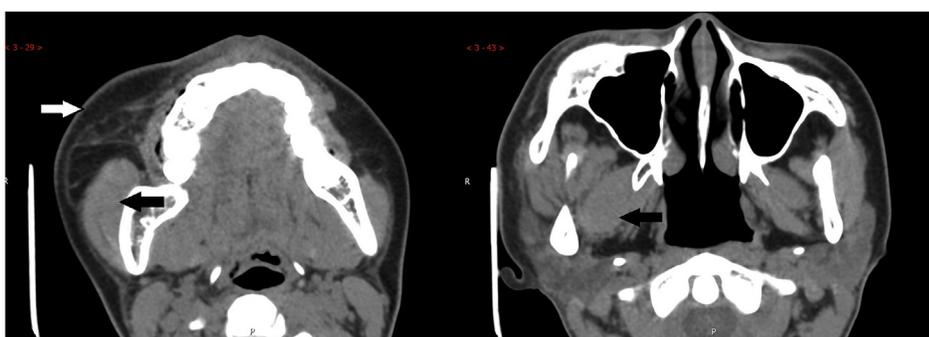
Axial computed tomography shows the fat infiltration in the right cheek subcutaneous layer (white arrow) and hypertrophy of right masseter and lateral pterygoid muscle (black arrow).
